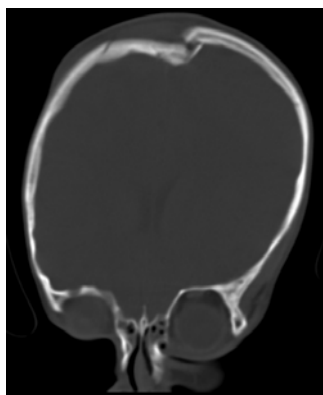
Coronal view of CT scan (bone window) showing the depressed fragment crossing the midline.
